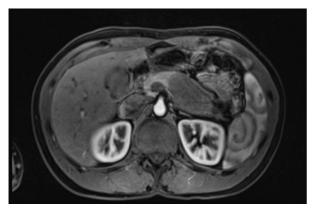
Abdominal MRI image of 3.6x6.4 cm mass in the body/tail of the pancreas.
